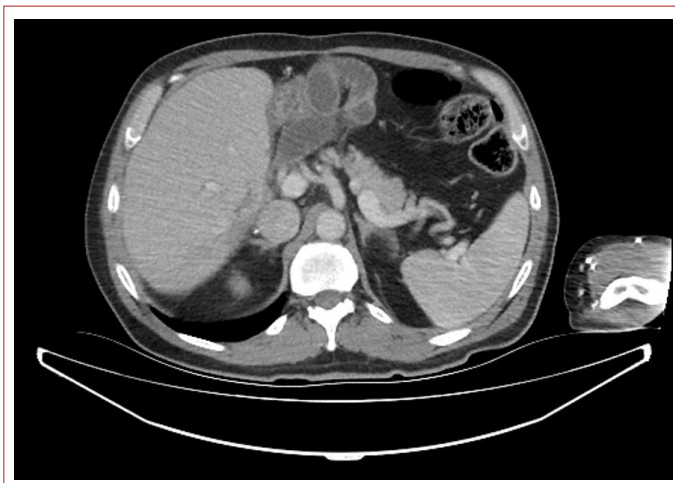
Adhesion appearance on Computed tomography.
